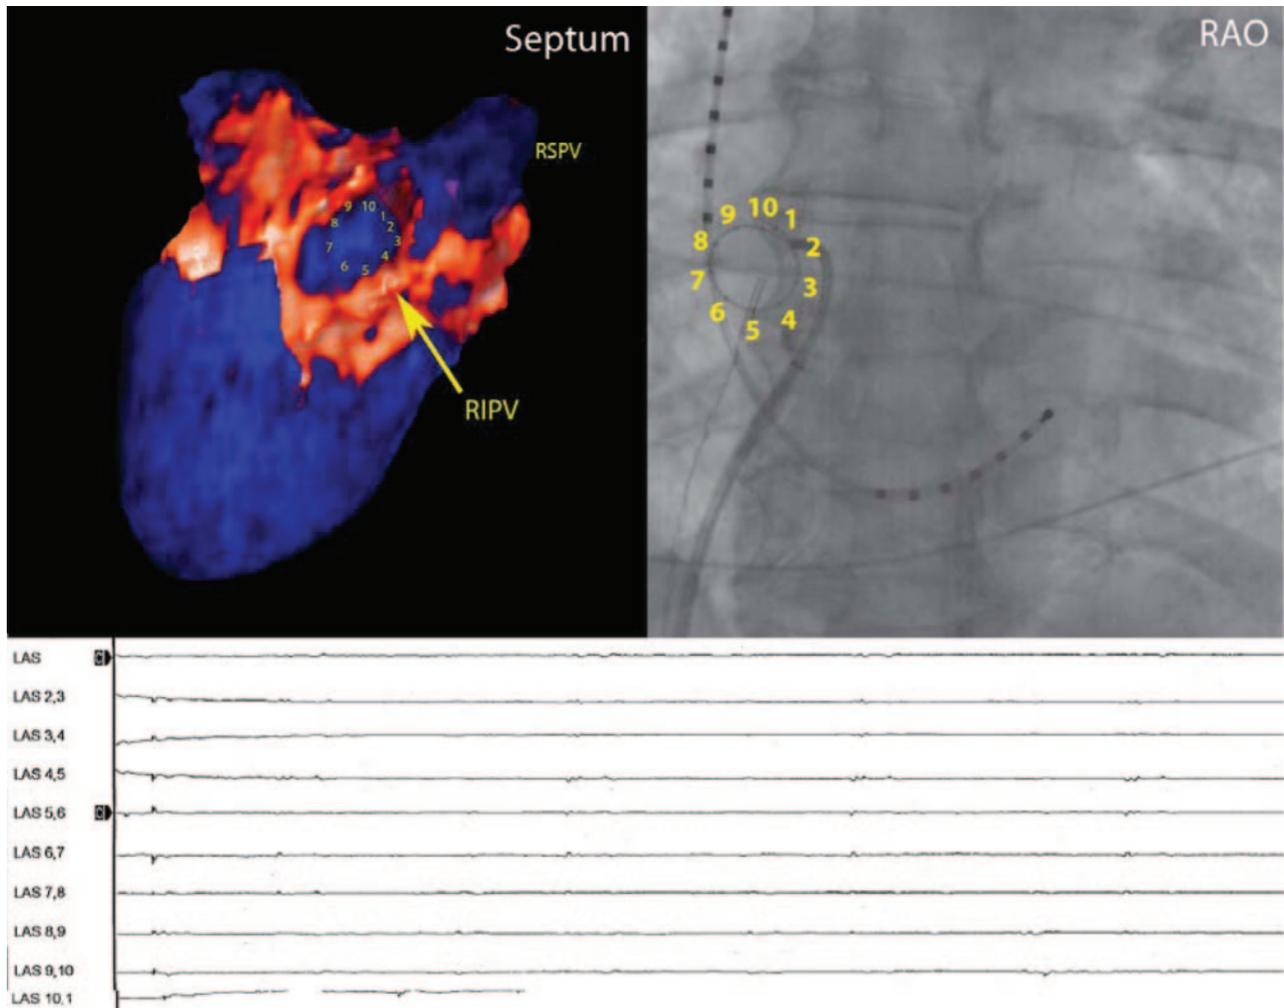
Complete anatomic and electric isolation. Patients who demonstrated complete anatomic scar on DE-MRI had no recovery of electric potentials on repeat examination. In this example, the upper left image demonstrates a lesion with complete anatomic scarring of the right superior PV. This vein demonstrated no recovery of electric potentials on repeat electrophysiology study.
